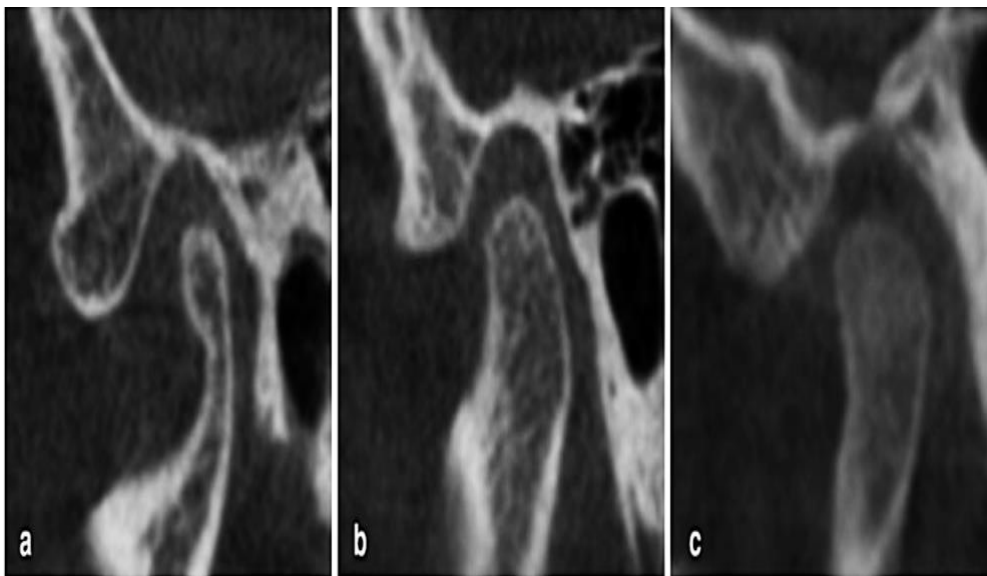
Types of articular eminence correction through cone-beam computed tomography (CBCT): Type I, Type II, Type III
